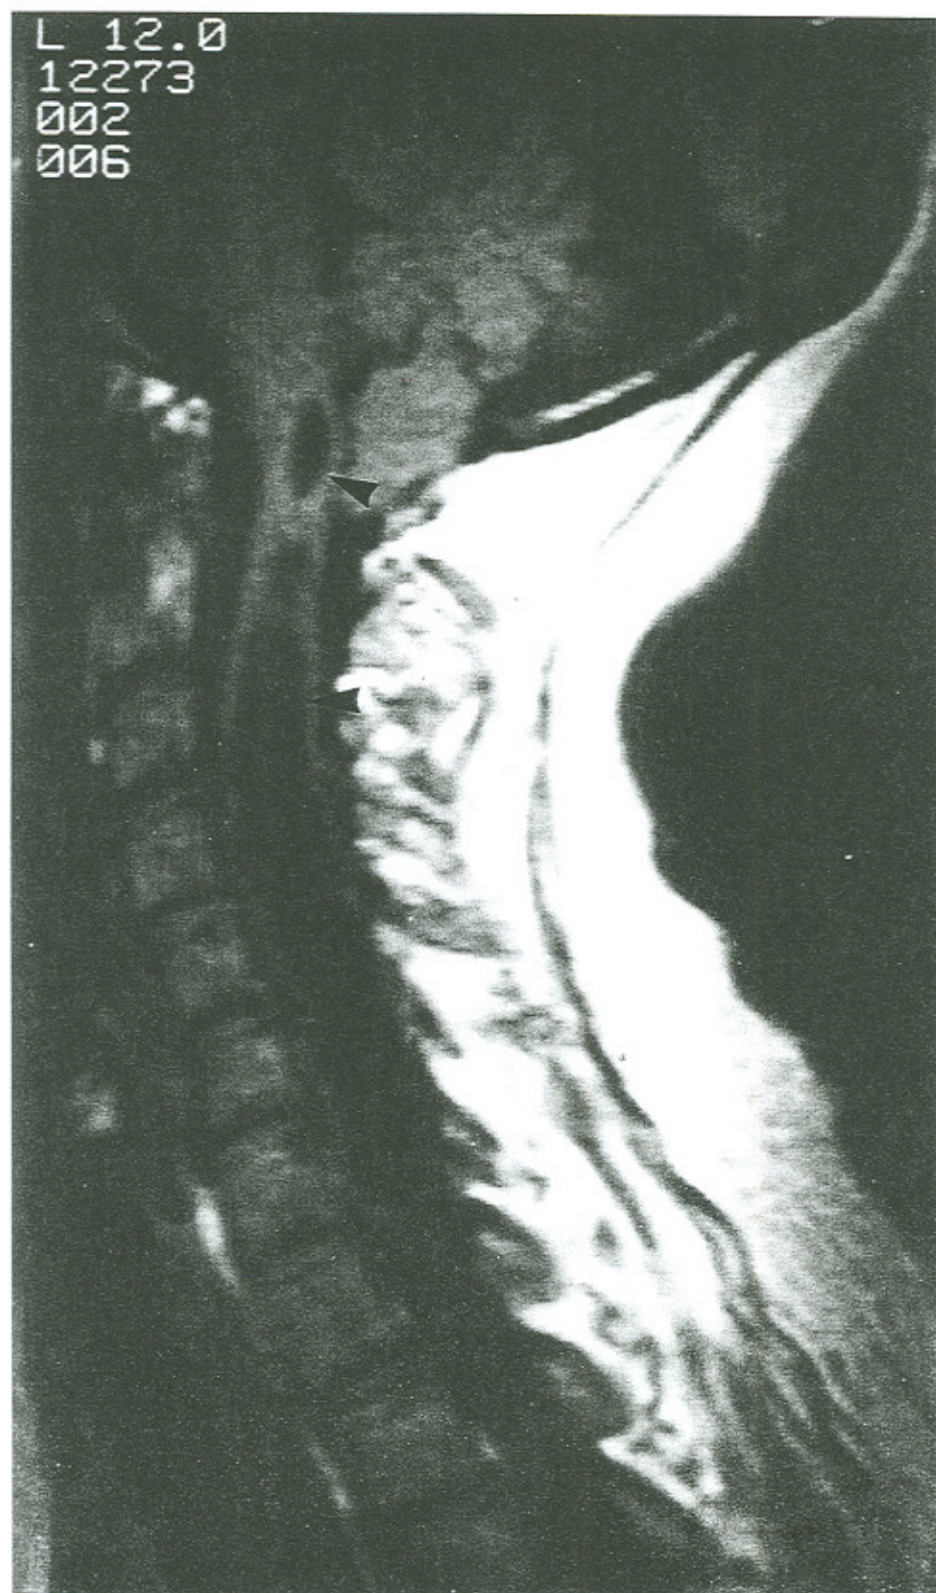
Sagittal T1 weighted MR image. There is herniation of the cerebellar tonsils to the level of the arches of C1. There is caudal displacement of the cerebellar hemispheres and elongation of the medulla. The cisterna magna is thinned. A small syrinx is present at the level of C1 and extends into the medulla (arrow). A large syrinx is present extending from C2 to C7 (arrow).
